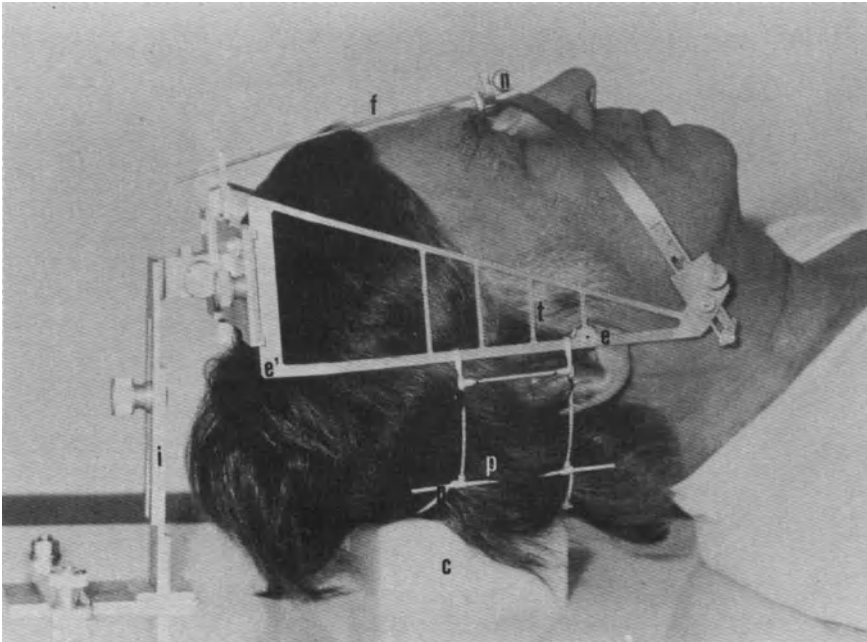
The CT/MRI adapter mounted to the author's head: f, frontal laterality indicator; n, nasion support; e, ear plug; é-e, posterior ear arm; p, posterior laterality indicator; i, immobilization device; c, plastic cushion.
